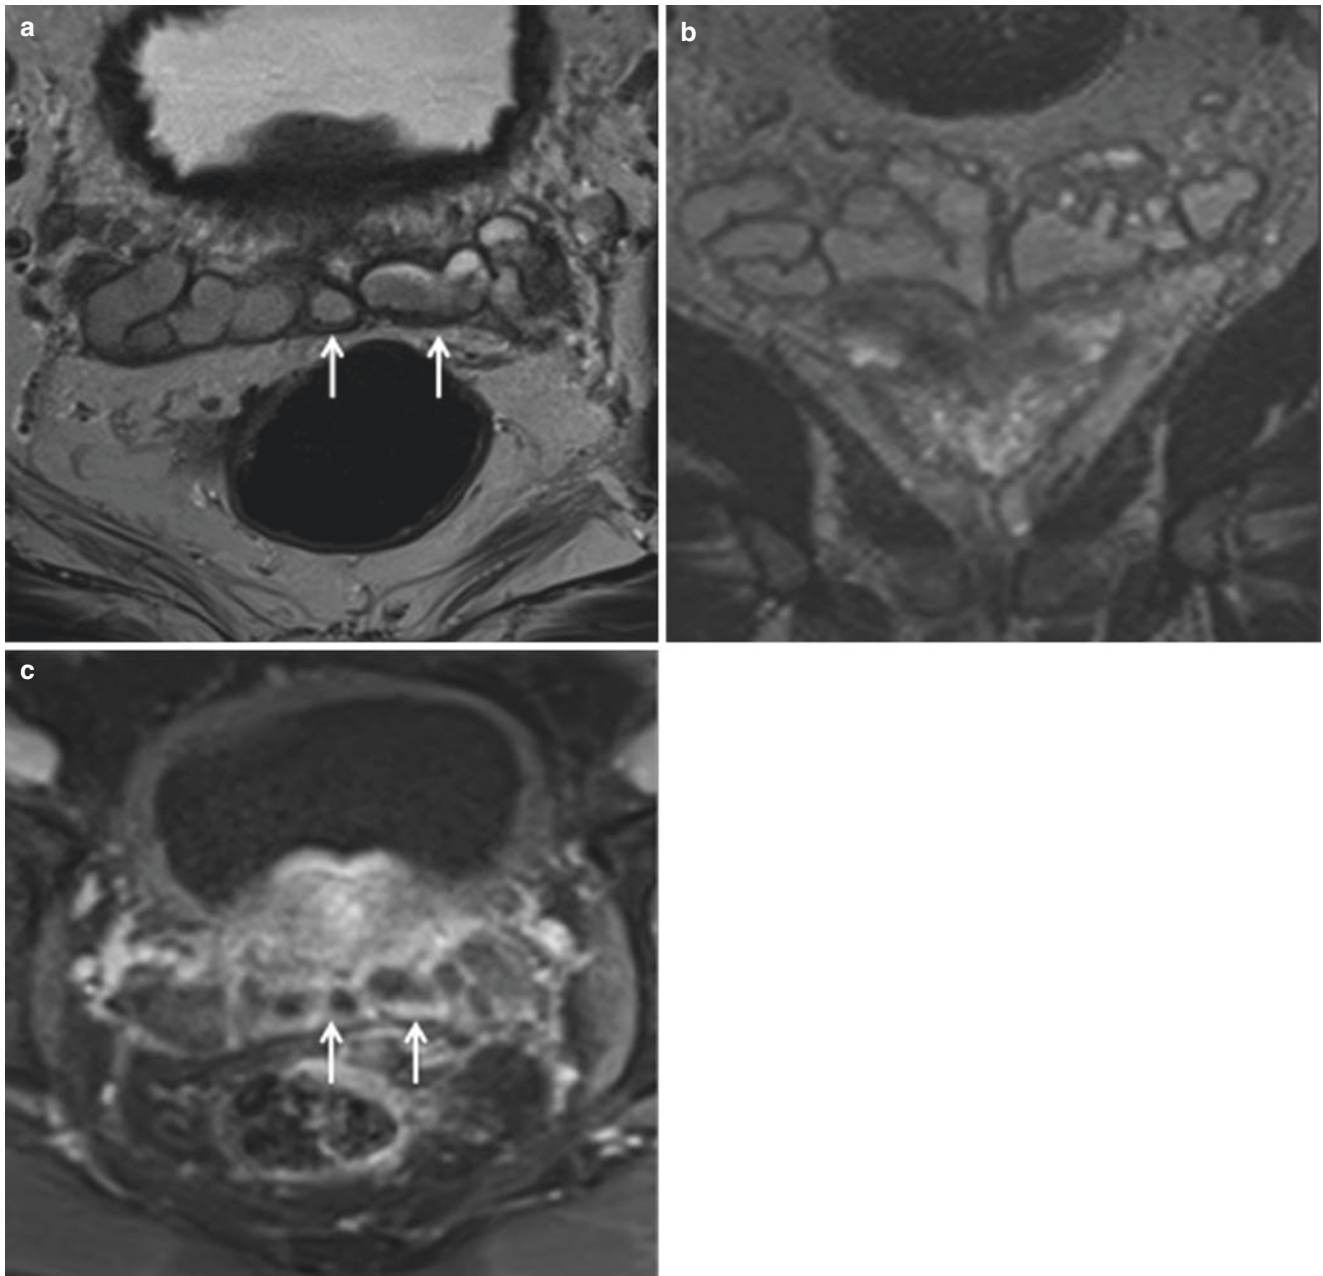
Seminal vesiculitis in a 34-year-old man with hematospermia. Axial (a), coronal (b) T2-weighted MR image and axial, (c) contrast-enhanced fat-suppressed T1 weight MR image show diffuse wall thickening of the SVs (arrows)
